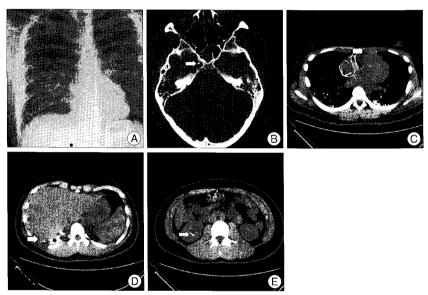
Postoperative radiologic findings. A: Chest X-ray demonstrating multiple radiopaque materials including increased pulmonary vascular markings. B: Brain CT showing metal droplet on right paraclinoidal area. C, D and E: Chest and abdomino-pelvic noncontrast CT view demonstrating radiopaque droplets at pulmonary vessel, coronary vessel, hepatic vessel, kidney parenchyma, low spinal canal, intermuscular space, and to other various parts of the body.
